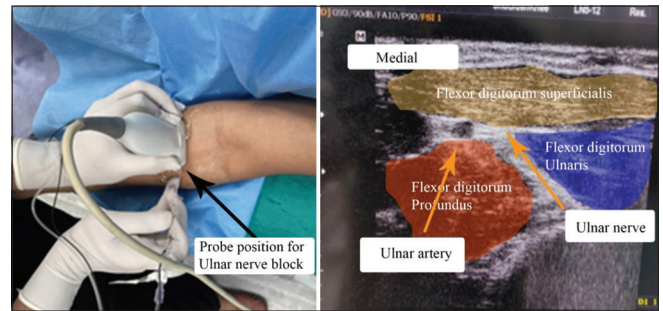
Probe position and corresponding sonographic view of ulnar nerve block. The target is the ulnar nerve 3–4 fingerbreadths distal to the elbow joint. The US probe was placed on the ventromedial aspect of the forearm. At this level, the nerve is situated just medial to the flexor carpi ulnaris, between the flexor digitorum profundus and superficialis. The needle was inserted in-plane medial to lateral direction and 6 mL of LA solution was deposited around the nerve.
